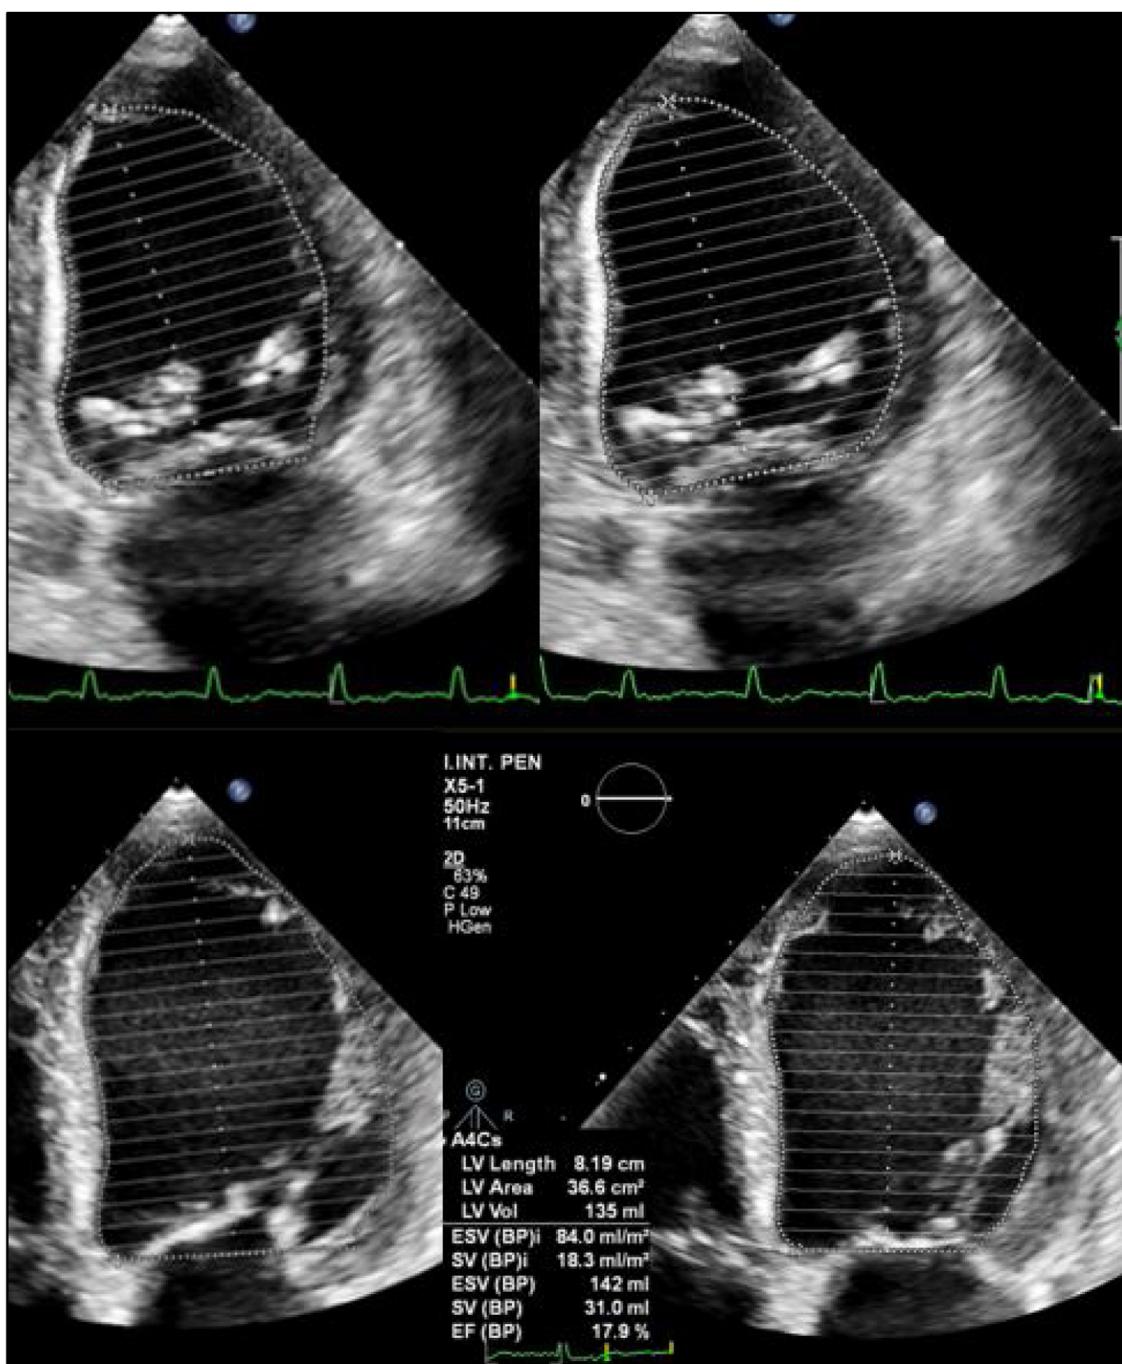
Biplane Simpson method using the end diastolic and end systolic apical 4- and 2- chamber views for estimation of LV volume and calculation of the ejection fraction.
